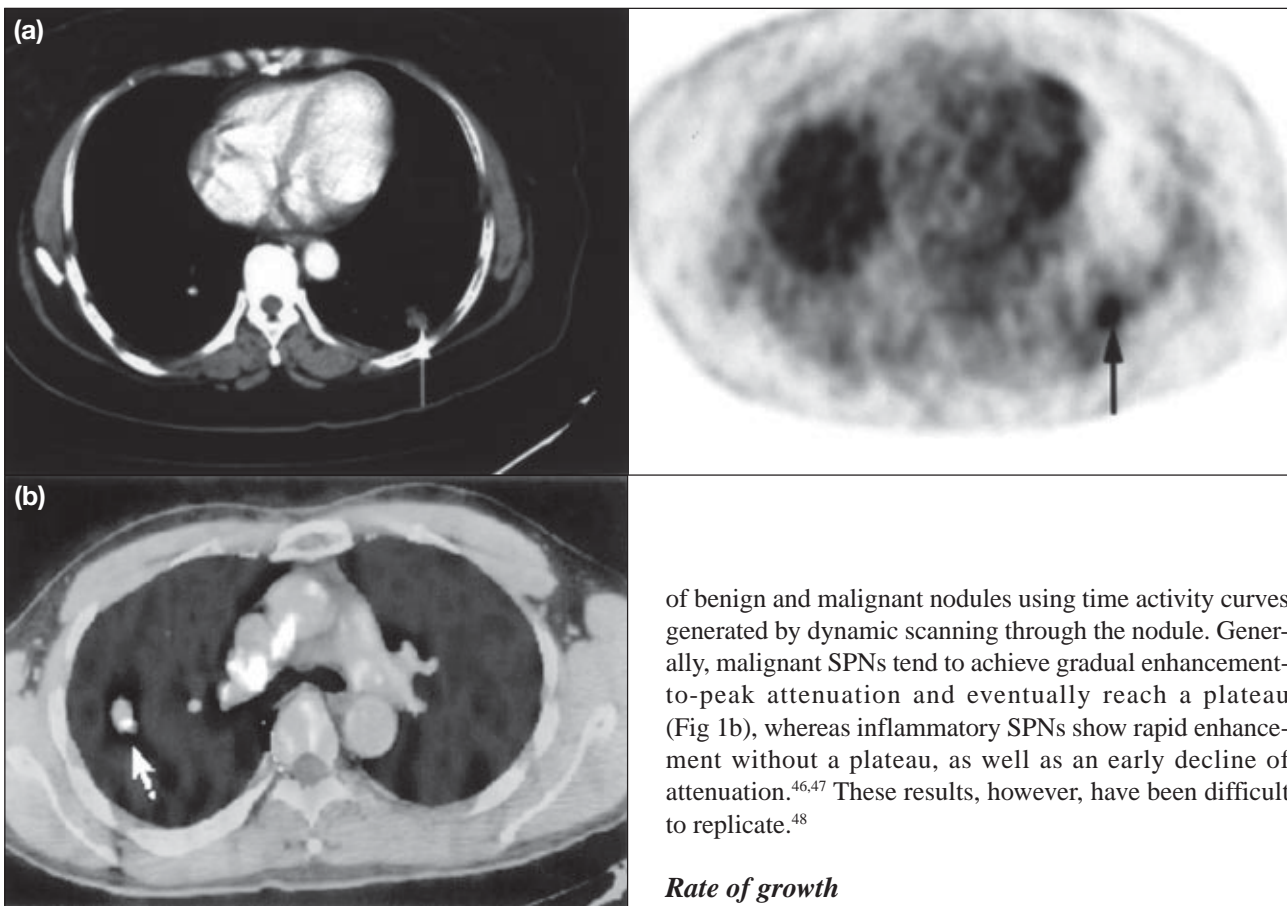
Positron-emission tomography/computed tomography scans
